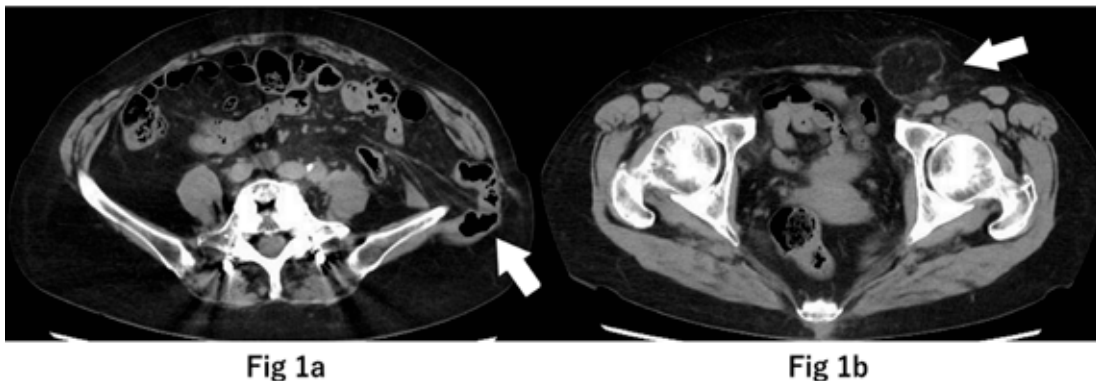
Preoperative computed tomography (CT) findings. (a) Herniation of the intestine above the left iliac crest (white arrow). (b) Omental herniation in the left inguinal region (white arrow).
